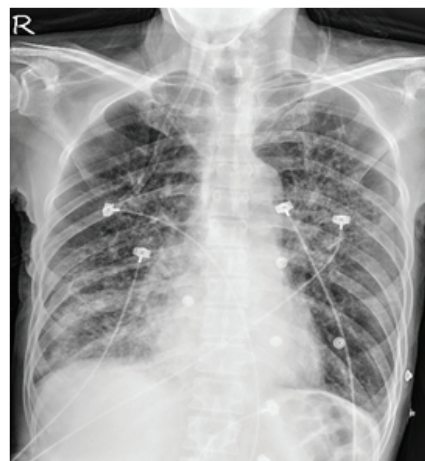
X-ray showing patchy opacity in the bilateral lungs.
